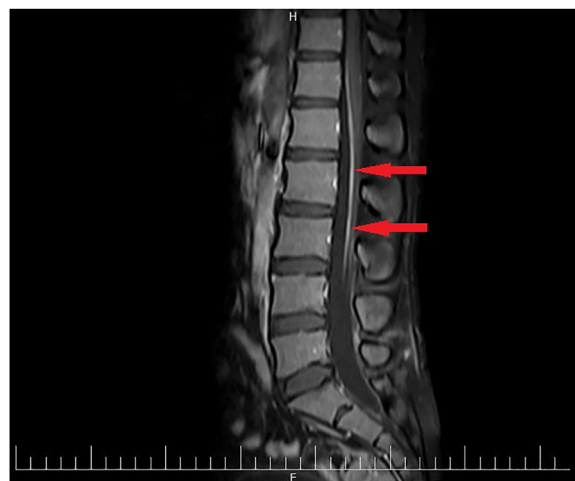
T1-weighted sagittal MRI with contrast view of the lumbosacral region. Arrows show roots enhancement in the lumbosacral region of the spine.
